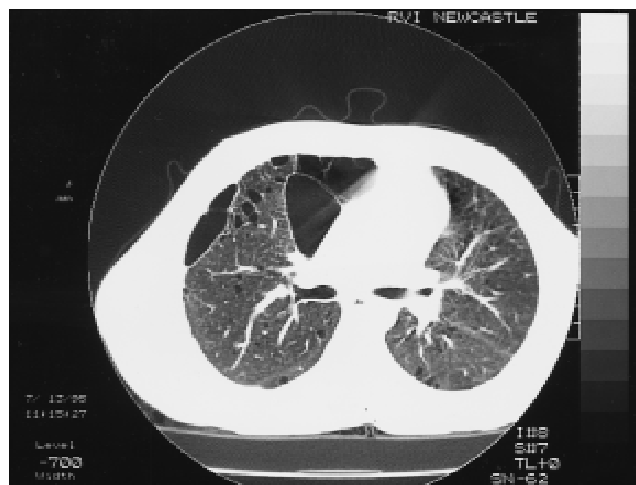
CT scan of the lungs of patient C following bilateral pleurectomy. Large apical cysts and multiple smaller bullae are present bilaterally.
